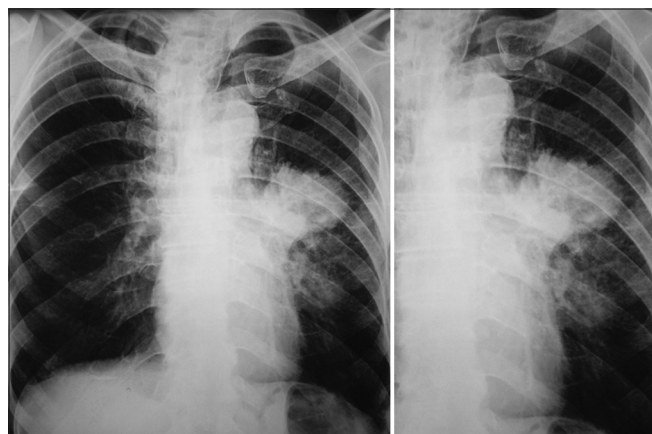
Chest X-ray posteroanterior view showing left hilar opacity with linear spreading margins and edges typical “Sunray sign.”
